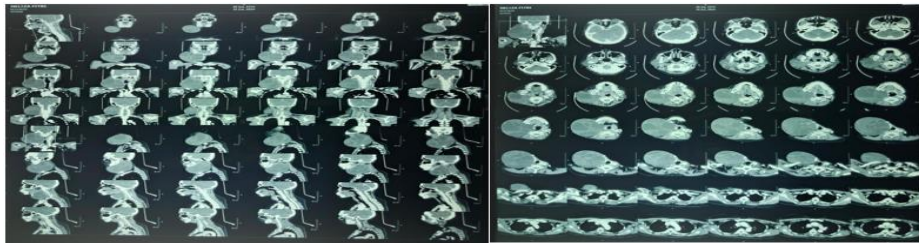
CT scan of the neck
